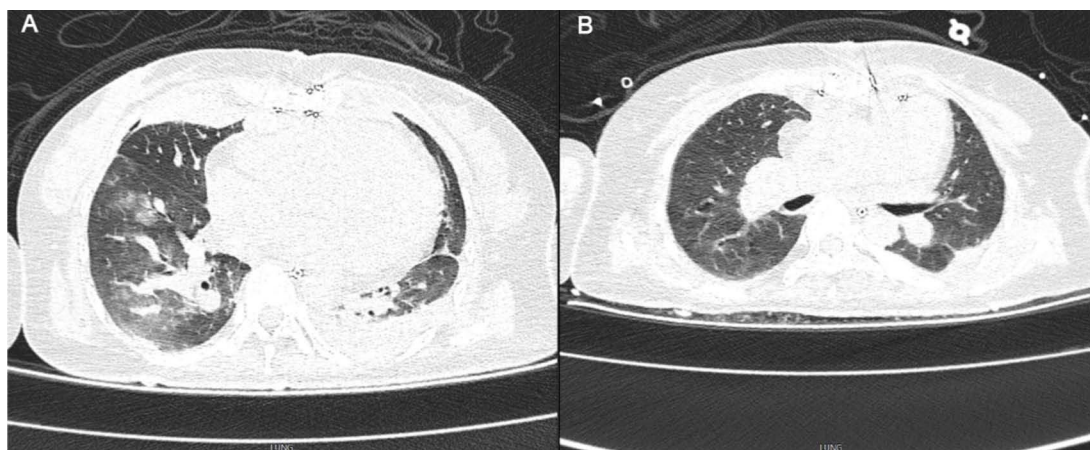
Chest CT image. (A) Initial CT showed widespread infections in both lungs; (B) CT shows significant lesion resorption 10 days post-treatment.
